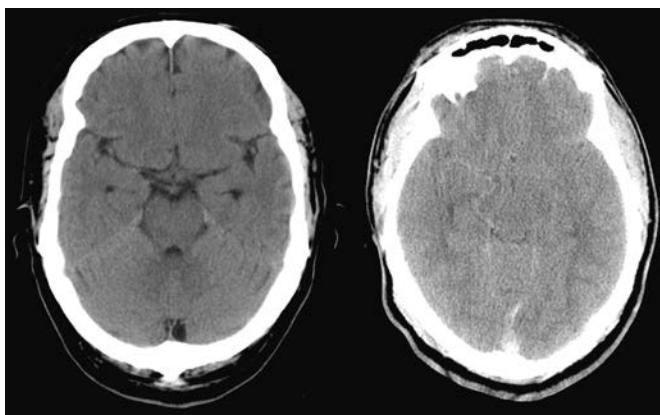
Computed tomography scan depicting normal (left) and compressed (right) basal cisterns. The basal, or perimesencephalic, cerebrospinal fluid space consists of the interpeduncular cistern (anterior), the ambient cisterns (lateral), and the quadrigeminal cisterns (posterior). In the right panel, the cisterns have been obliterated in a patient with diffuse cerebral swelling (caused by sagittal sinus thrombosis). (Courtesy Ivan Petrovitch, MD)
